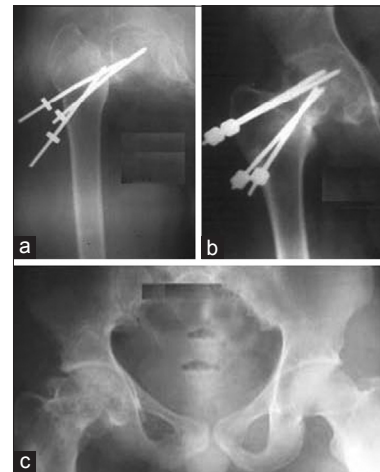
X-ray of right hip joint in a 16 year old male showing (a) nonunion of six months duration following failed Moore's pins *in situ*; neck shaft angle 85° in varus, (b) status at two years postoperatively, (c) status at 18 years postoperatively; there was 2" shortening with painless hip; neck shaft angle restored to 126°
